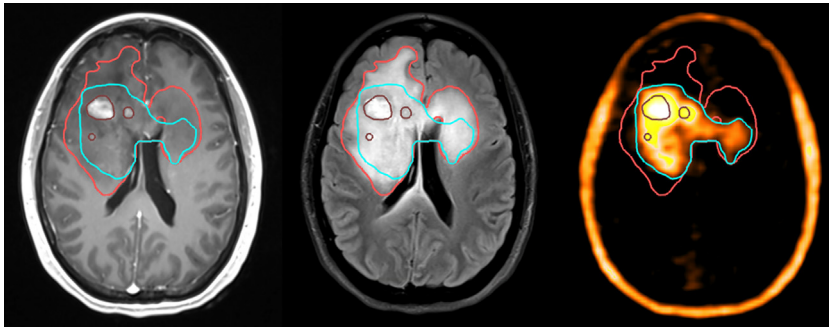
Contrast-enhanced T1-weighted (left) and fluid-attenuated inversion recovery (middle) magnetic resonance imaging and F18-Fluciclovine positron emission tomography (right) of the brain at a 3-week interval after the previous imaging study.
